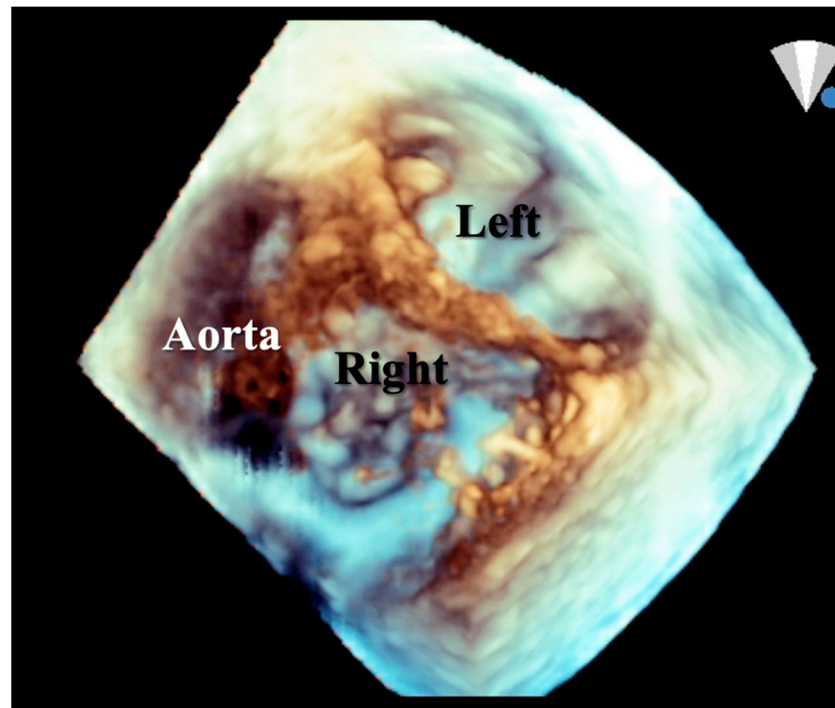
Short axis 3-D echocardiographic section in a heart with partial AVSD with left and right valve orifices. Part of the ventricular septum can be seen between these orifices.
